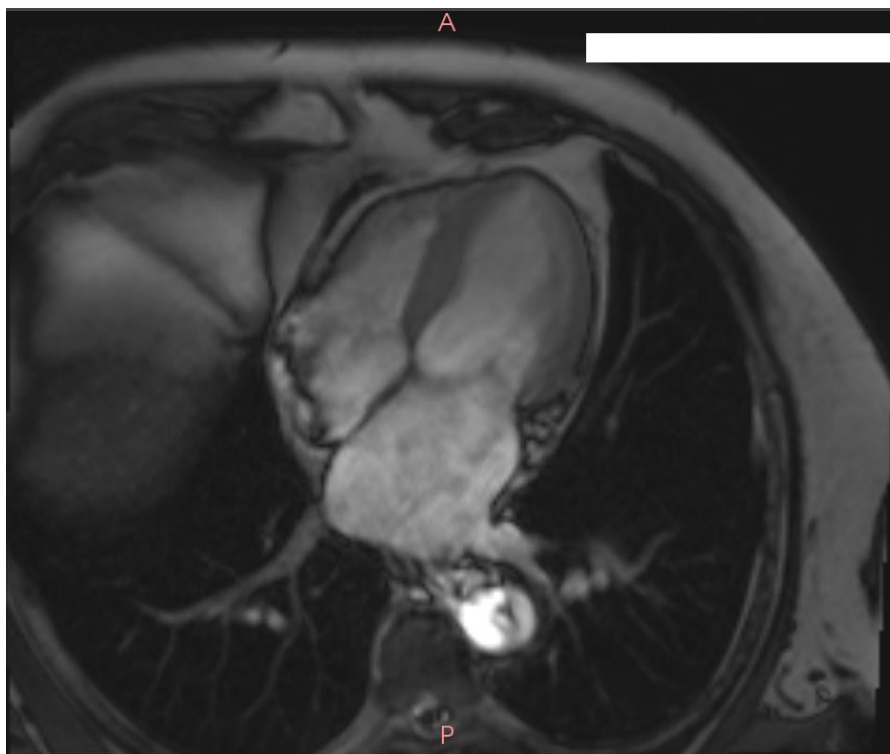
Cardiac magnetic resonance imaging in 3-chamber cine, showing thickening at the level of the interventricular septum, characteristic of cardiac amyloidosis
